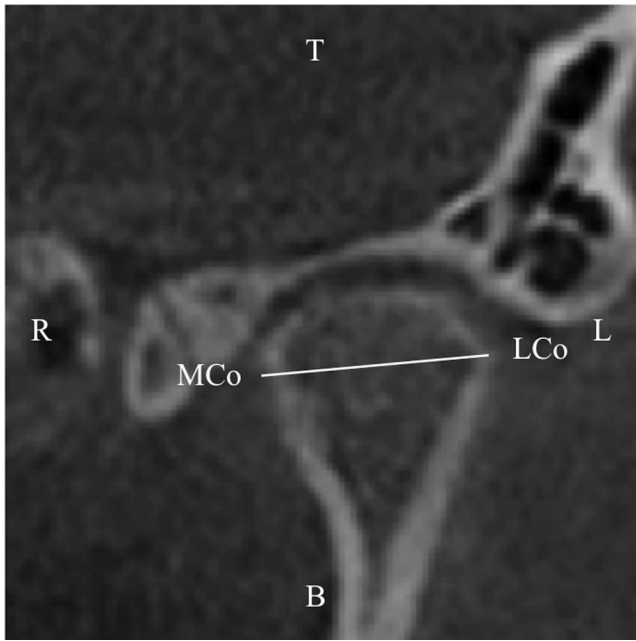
The condylar width on the coronal CBCT image. T = top direction, B = bottom direction, L = left direction, R = right direction, LCo = the most lateral mandibular condyle point, and MCo = the most medial mandibular condyle point.
